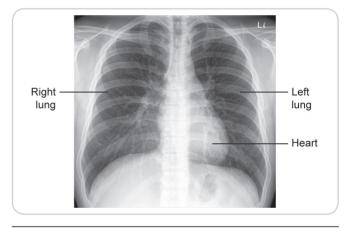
Posteroanterior view of X-ray chest
